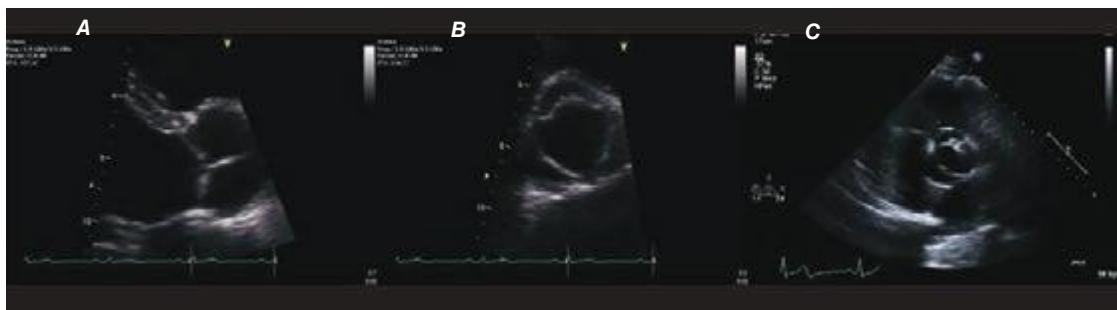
19 Normal aortic valve in the parasternal long-axis view (A) and short-axis view (B), and bicuspid aortic valve showing typical 10 o'clock to 4 o'clock leaflet orientation (C).
